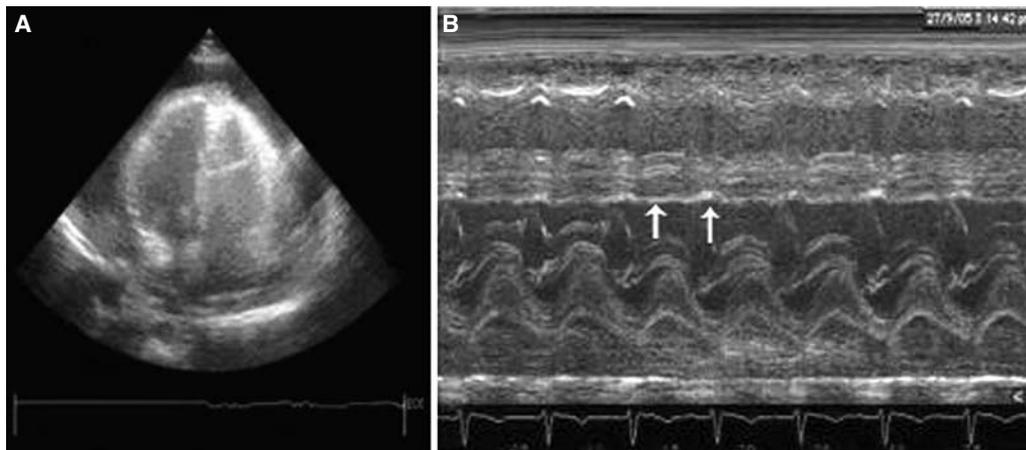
(A) Pericardial fluid completely surrounding the heart in the apical four-chamber view. (B) Parasternal long-axis M-mode image showing severe septal hypokinesia (arrows) due to left ventricular systolic dysfunction after pericardiocentesis. Posterior wall contractility is normal.
